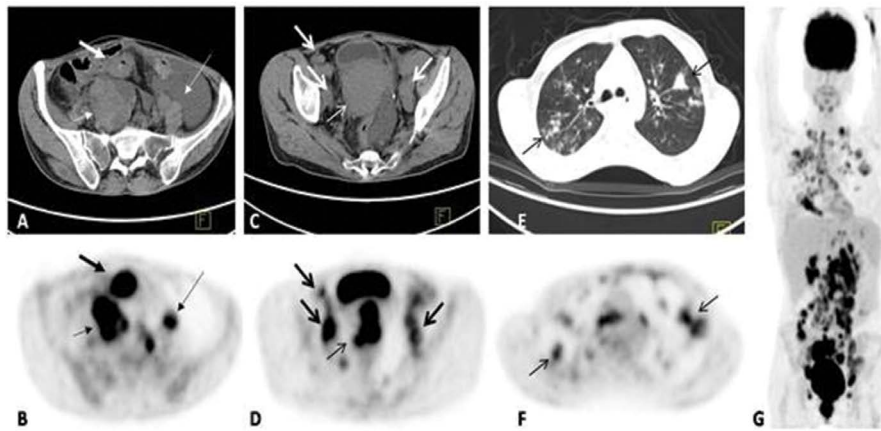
[¹⁸F]FDG PET-CT scan showing increased [¹⁸F]FDG uptakes at right ovo adnexal mass, endometrium [Maximum Standardised Uptake Value (SUVmax)] 15.70 and 15.09 respectively; A–D. Thin white and black arrows; lymph nodes at several regions prominently in abdominopelvic regions (SUVmax 13.16); C, D. White and black thick arrows and parenchymal lung lesions (SUVmax 9.96); E, F. Arrows; Intense accumulation of [¹⁸F]FDG in multiple lymph nodes, both lungs and genital tract can completely be seen on Maximum intensity projection image (MIP) of [¹⁸F]FDG PET/CT scan (G)
